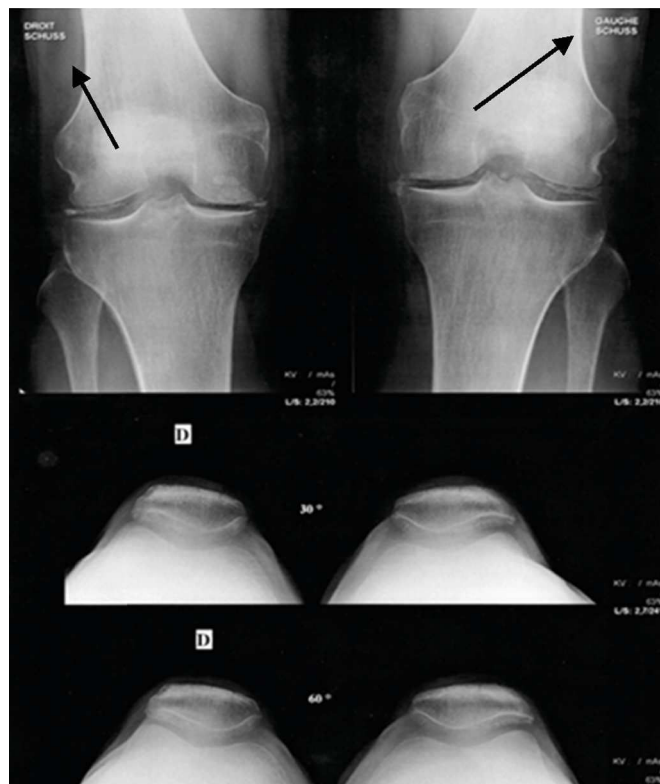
Knee radiograph showing bilateral meniscal calcifications.
